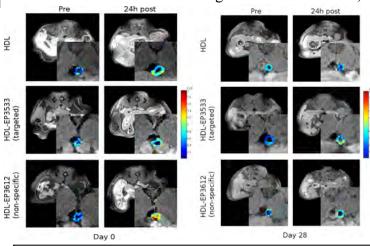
In vivo MR imaging of abdominal aortas during plaque regression.
